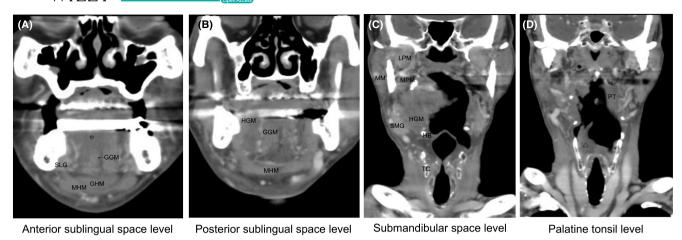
Coronal CT images. (A) Anterior sublingual space level. (B) Posterior sublingual space level. (C) Submandibular space level. (D) Palatine tonsil level. GGM, genioglossus muscle; GHM, geniohyoid muscle; HGM, hyoglossus muscle; MHM, mylohyoid muscle; MM, masseter muscle; MPM, medial pterygoid muscle; LPM, lateral pterygoid muscle; SMG, submandibular gland; SLG, sublingual gland; PT, palatine tonsil; HG, hyoid bone; TC, thyroid cartilage. Asterisk reveals diffuse inflammation of the tongue parenchyma. Triangle reveals laryngeal edema.
